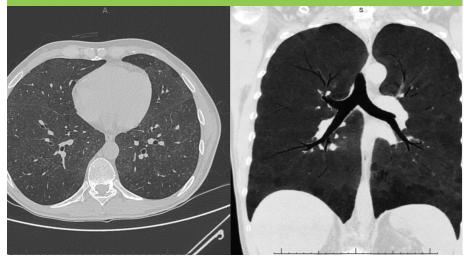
CT for NSIP with progressive fibrosing phenotype
